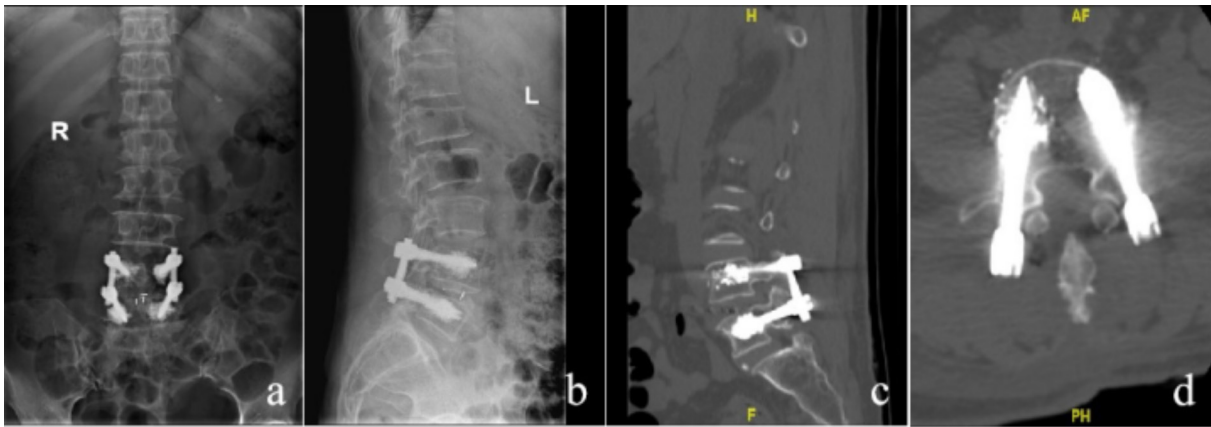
a-b, 3 days postoperatively, frontal and lateral radiographs of the lumbar spine showed the lumbar internal fixation in place and no cement leakage. Figure c-d, 3 days after surgery, CT of the lumbar spine showed good position of pedicle screws and satisfactory distribution of bone cement.
